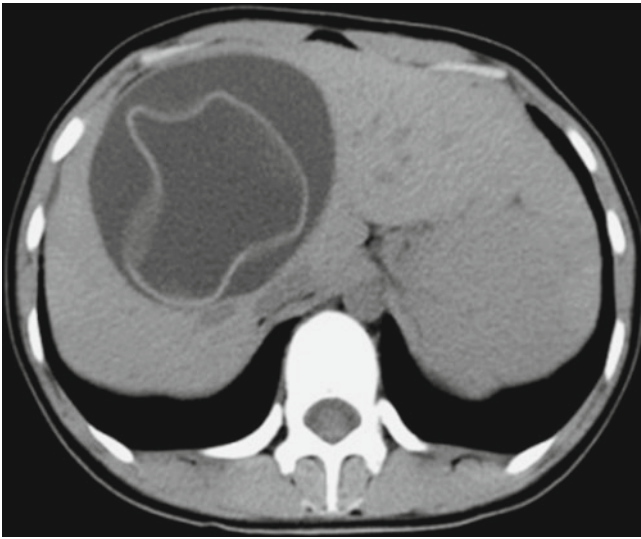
Hepatic hydatid rupture. Plain CT scanning demonstrates collapse and shrinkage of the ruptured hydatid cystic wall, which is floating in the cystic fluid to form typical ribbon sign
